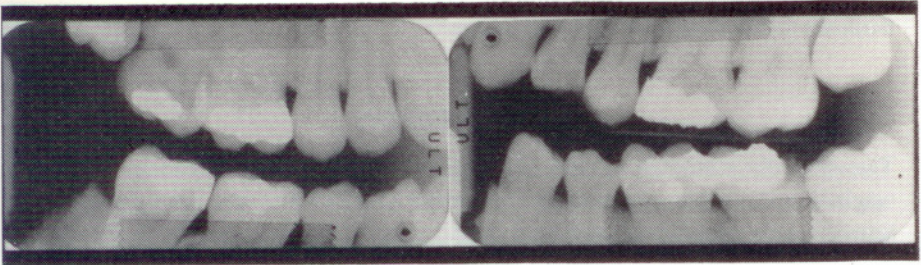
Postmortem dental radiographs of the jaws of victim 8/91.
